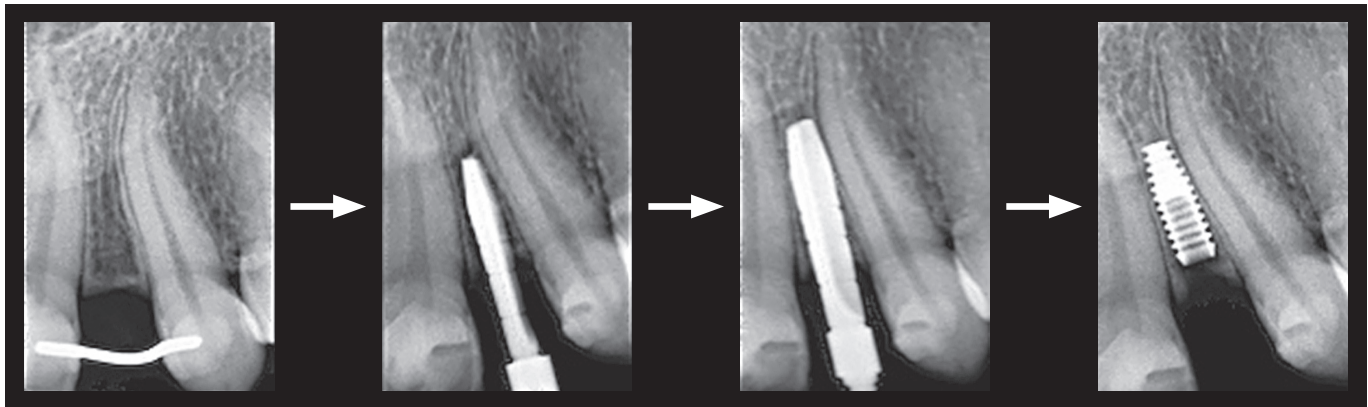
Radiographic follow-up of the interproximal root spreading technique. Note the 2.5mm and 3.0mm hand reamers sliding between the roots and making space for the 3.0mm diameter implant, which was placed 3.0mm under the crestal bone level.
